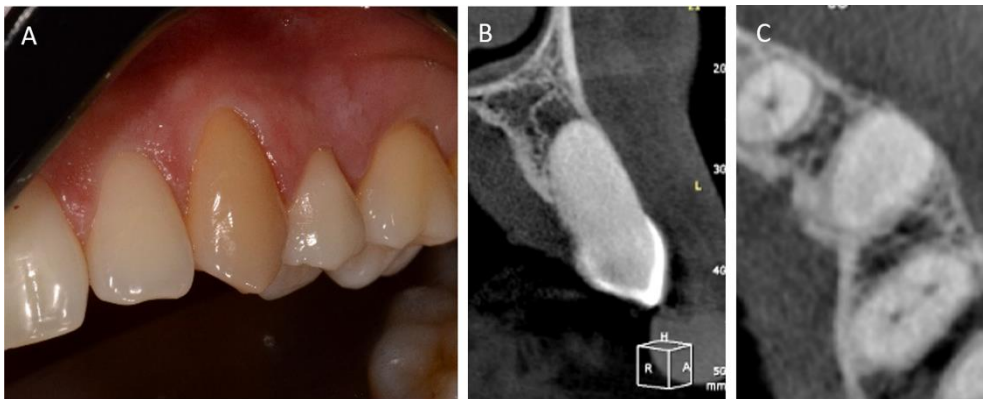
(A) Tooth 23 with significant discoloration of the crown (yellowing). (B, C) Images of the initial CBCT showing severe calcification of the root canal in its entire length and the presence of periapical bone rarefaction. (B) Coronal and (C) axial views showing the complete absence of the root canal image.
